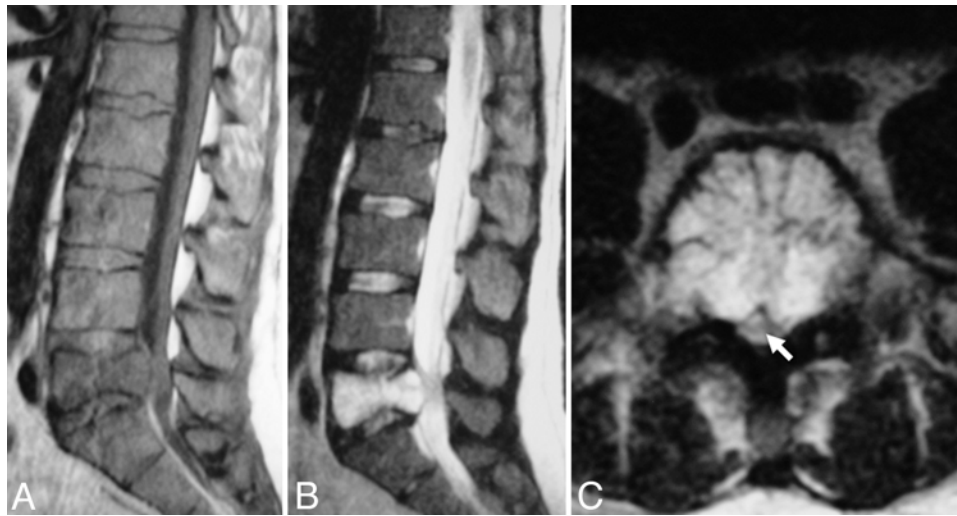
Sagittal T1- (A) and T2-weighted (B) MR images in a patient with a very large hemangioma that fractured, causing compression of the cauda equina as noted on axial T2-weighted imaging (arrow, C).
